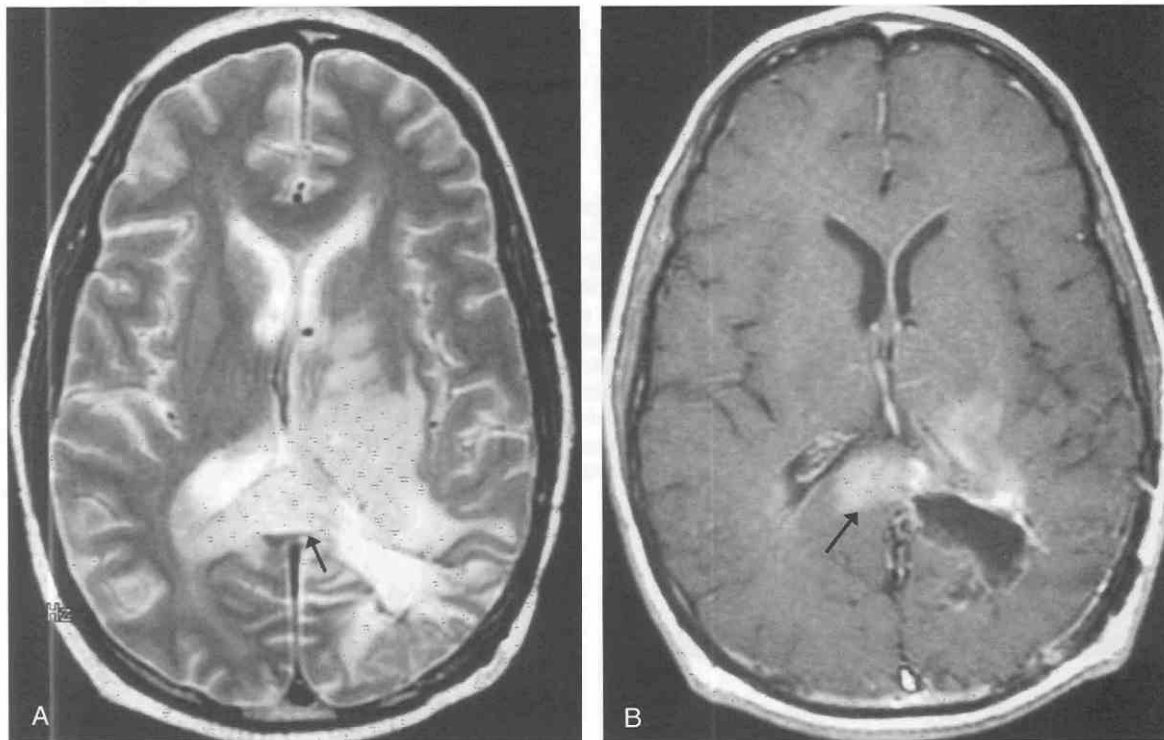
Left deep frontoparietal glioblastoma with extension through corpus callosum. A, Axial T2-weighted MR image through the level of the upper third ventricle. A large area of diffuse hyperintensity involves the left posterior thalamus and basal ganglia and extends posteriorly to involve the subcortical white matter in the left parietooccipital convexity. It is not possible on this image to either define the tumor margins or to separate gross tumor from surrounding edema. The third ventricle and the flow voids of the two parallel internal cerebral veins are bowed to the right of the midline secondary to the left sided deep mass effect. Note that this hyperintensity also extends into and widens the splenium of the corpus callosum (arrow), crossing the midline into the contralateral hemisphere and creating a “butterfly glioma” pattern. B, Axial T1-weighted image following intravenous gadolinium demonstrates patchy heterogeneous contrast enhancement within the splenium (arrow) and surrounding the dilated and posteriorly displaced atrium of the left lateral ventricle; the tumor has blocked the posterior portion of the ventricle, and the marginal contrast enhancement of the atrium suggests subependymal tumor spread.
